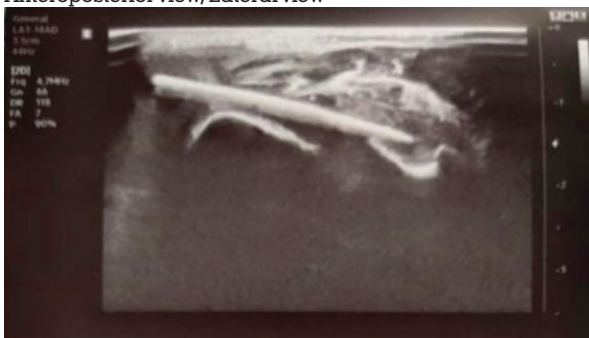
Tooth pick found in ultrasonography picture
